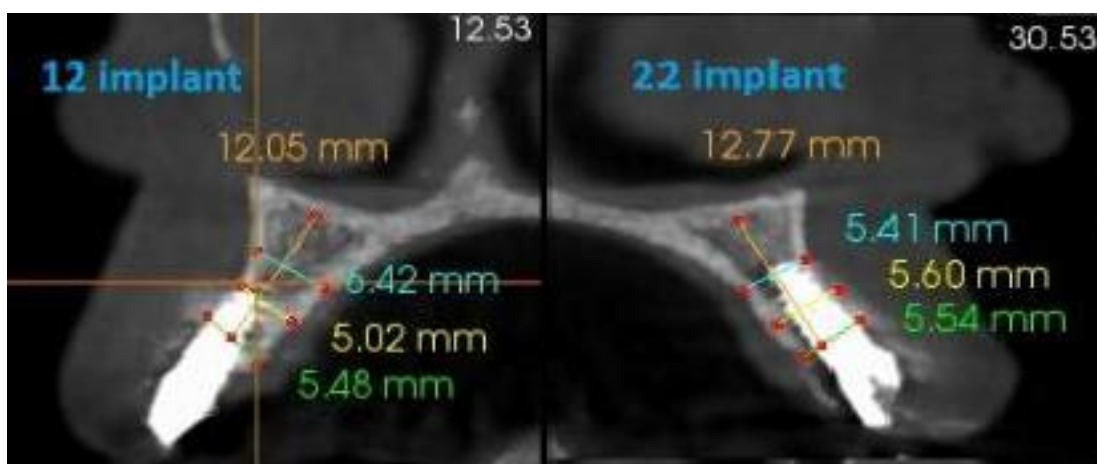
Post operation CBCT
